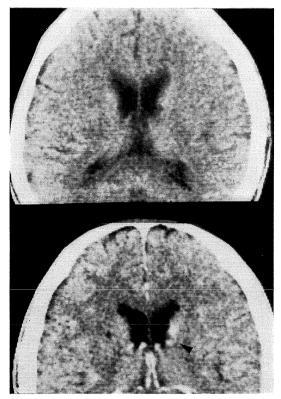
CT scans on the 22nd day after onset. Plain CT (upper) and enhanced CT (lower). Arrow shows the image of aneurysm.
